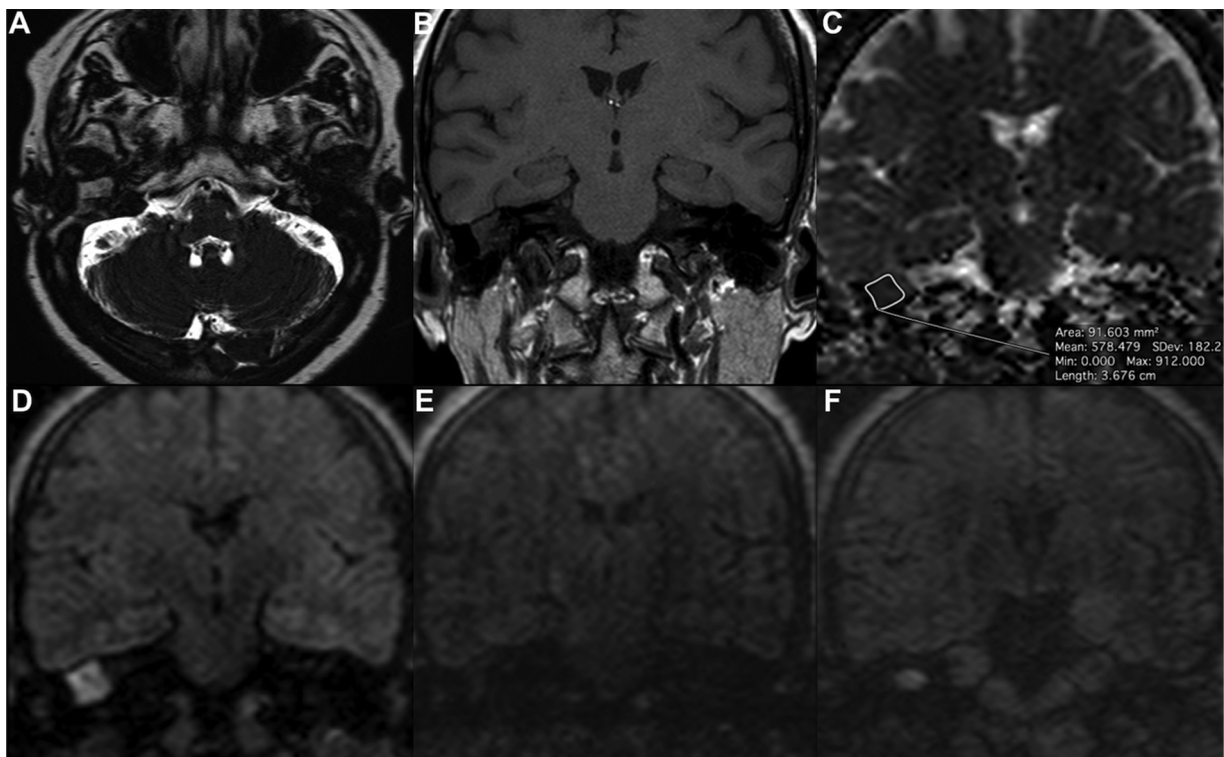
Right middle ear cholesteatoma in a 63-year-old woman with evidence of recurrence after about 28 months from first-look surgery. (A–D) Baseline MRI examination: (A) axial T2w 3D TSE; (B) coronal T1w SE; (C) coronal ADC map showing the co-registered ROI within lesion's margins; (D) coronal MSH non-EPI DWI. (E) Coronal MSH non-EPI DWI 3 months after first-look surgery, showing absence of residual disease. (F) Coronal MSH non-EPI DWI 28 months after first-look surgery, showing recurrent cholesteatoma.
